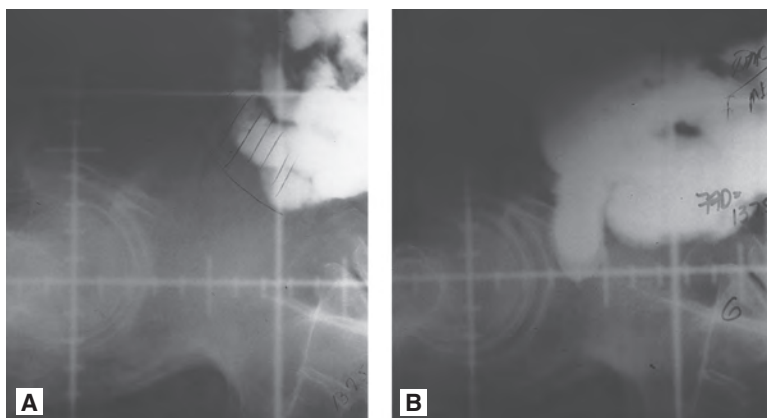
A,B: Lateral radiographs with and without bladder distention in a patient with contrast in small intestine.
